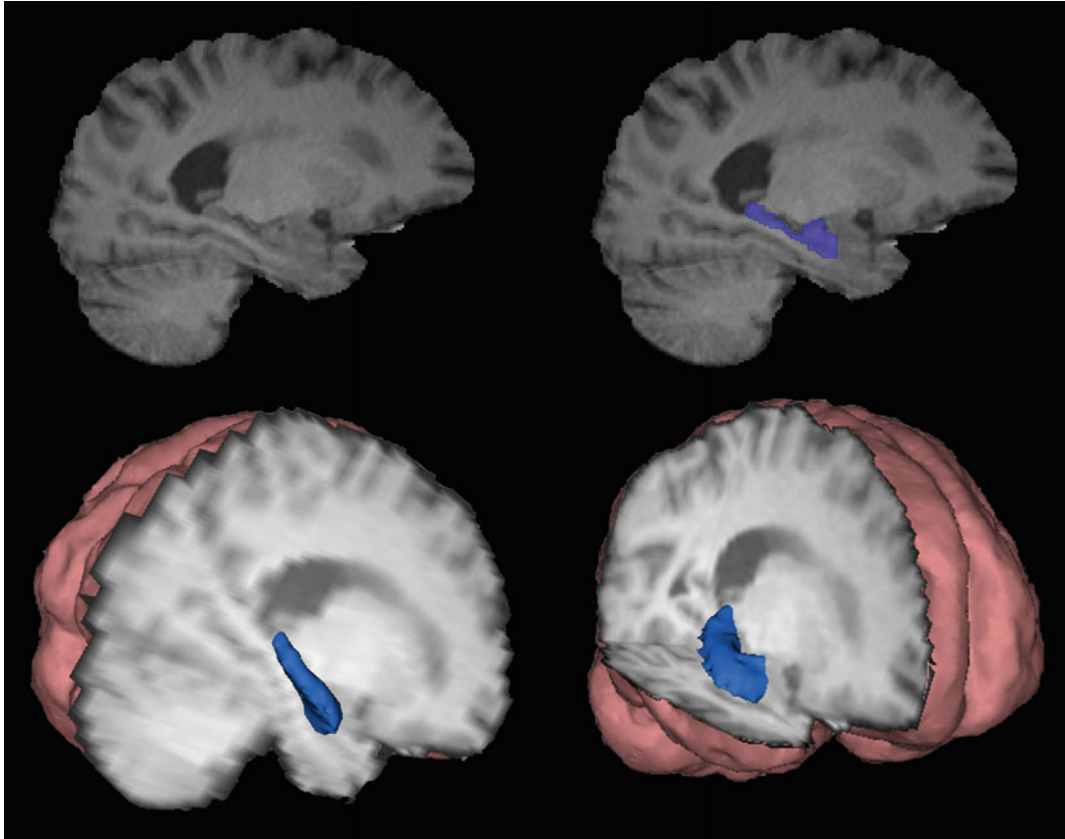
Segmentation of the hippocampus (in blue) from T1 MRI (top panel) using FreeSurfer tools (Fischl et al. 2002). The 3D renderings (bottom panel) are designed to
